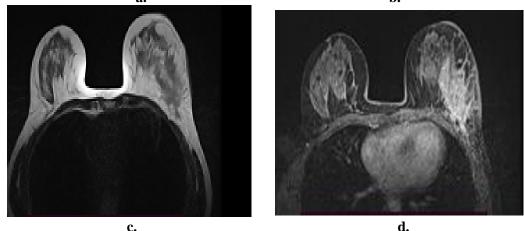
A 35-year-old female presented with left side enlarging breast mass, pain, and skin inflammation. (a) MRI turbo inversion recovery magnitude (TIRM) sequence shows asymmetrical increased signal intensity (breast edema) with overlying skin thickening, trabecullation, and multiple dilated ducts toward the nipple. (b) TIRM sequence single left side enlarged lymph node with preserved fatty hilum. (c) T2 intermediate to high signal intensity changes confined to lateral quadrant (d) post-contrast, regional heterogeneous non mass like enhancement.
